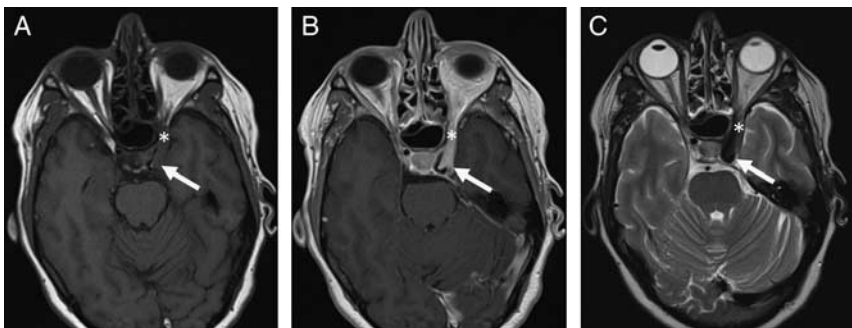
45-year-old woman presented with left eye pain and diplopia and subsequently improved after a 6-week course of steroids. Magnetic resonance imaging findings are consistent with Tolosa Hunt syndrome. Axial T1-weighted precontrast (A), postcontrast (B), and T2-weighted imaging (C) demonstrates enhancing T1 isointense, T2 hypointense enlargement of the left cavernous sinus (white arrows) extending to the orbital apex (white asterisks).
